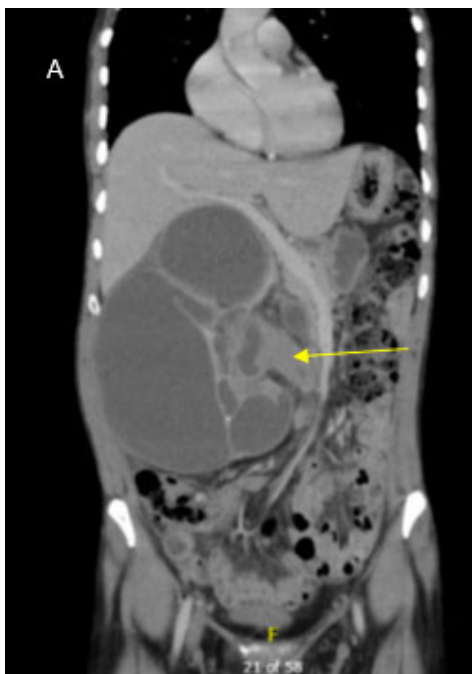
Pre-operative images: (A) Enhanced CT coronal section showing severe right hydronephrosis with soft tissue mass in the renal pelvis and upper ureter. (B) Enhanced CT axial section showing urinary bladder mass with calcification. (C) CT axial section in delayed phase showing thickening of bladder wall with filling defect.
